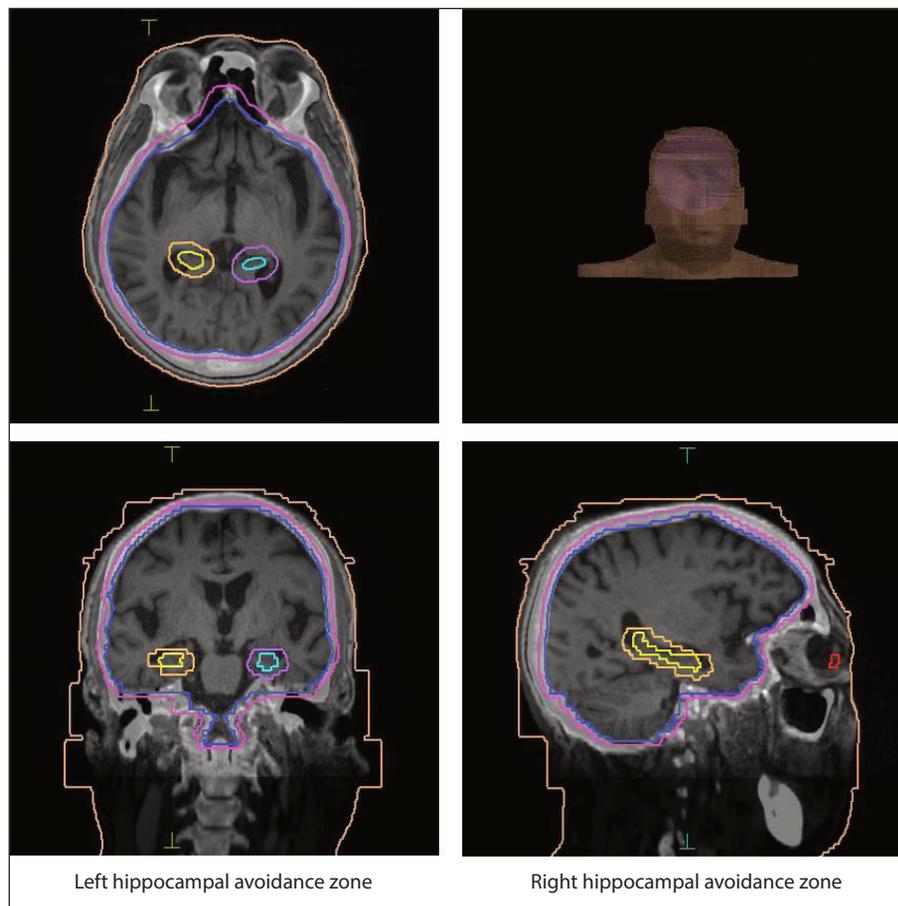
Magnetic resonance imaging (MRI) of the brain showing hippocampus in axial sections, the hippocampal avoidance zone in axial, coronal and sagittal sections. Source: TPS
